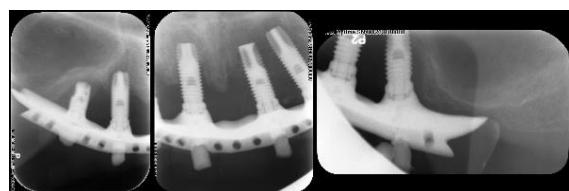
Radiographs showing complete loss of osseointegration, with significant destruction of the hard tissues, in the form of (destructive) cupping bone loss, quite unlike the benign failure of smooth surface implants
